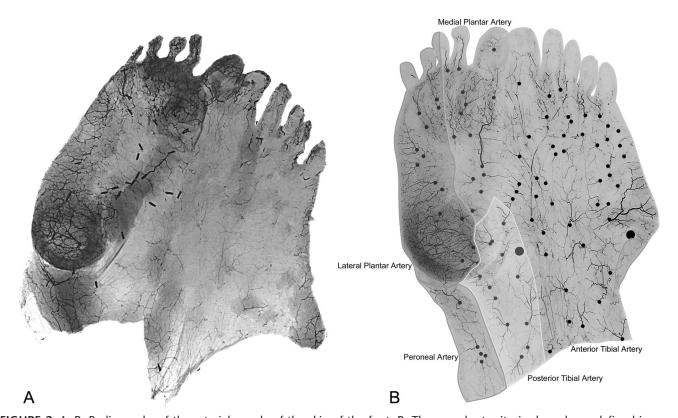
A, B, Radiographs of the arterial supply of the skin of the foot. B, The vascular territories have been defined in terms of the source artery. Dots mark the cutaneous perforators.
